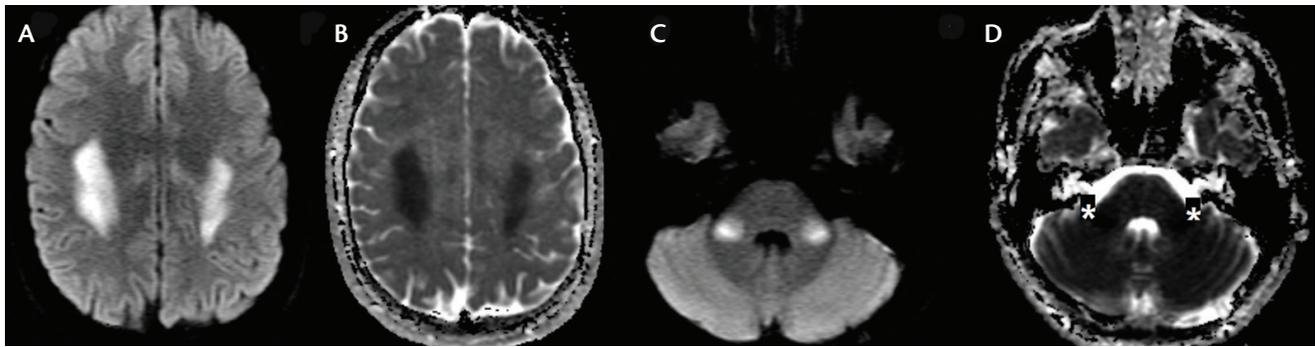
Brain MRI at 17 years of age. Diffusion-weighted image sequence (A, C) and apparent diffusion coefficient (B, D) showing restricted diffusion in the centrum semiovale (A, B) and the cerebellar peduncles (C, D).
